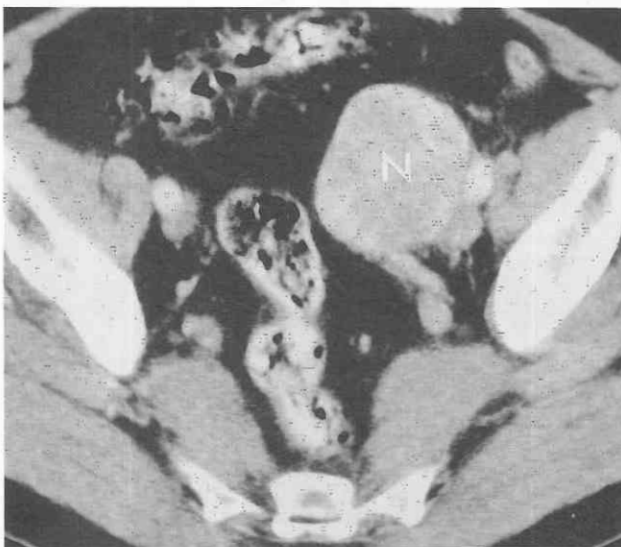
Lymph node metastasis. CT scan through the iliac vascular pedicles shows an enhancing left external iliac nodal metastasis (N) from newly diagnosed high-grade bladder cancer.
